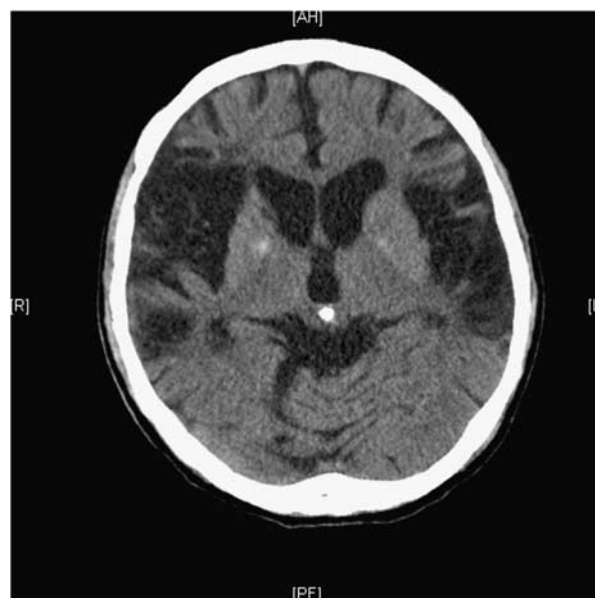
Representative computed tomography scan of the patient's brain revealed large encephalomalacia change of bilateral insula and operculum areas. Prominent sulci and cisterns suggest cortical atrophy. Mild ventriculomegaly and calcification in arterial wall suggest intracranial atherosclerosis.
